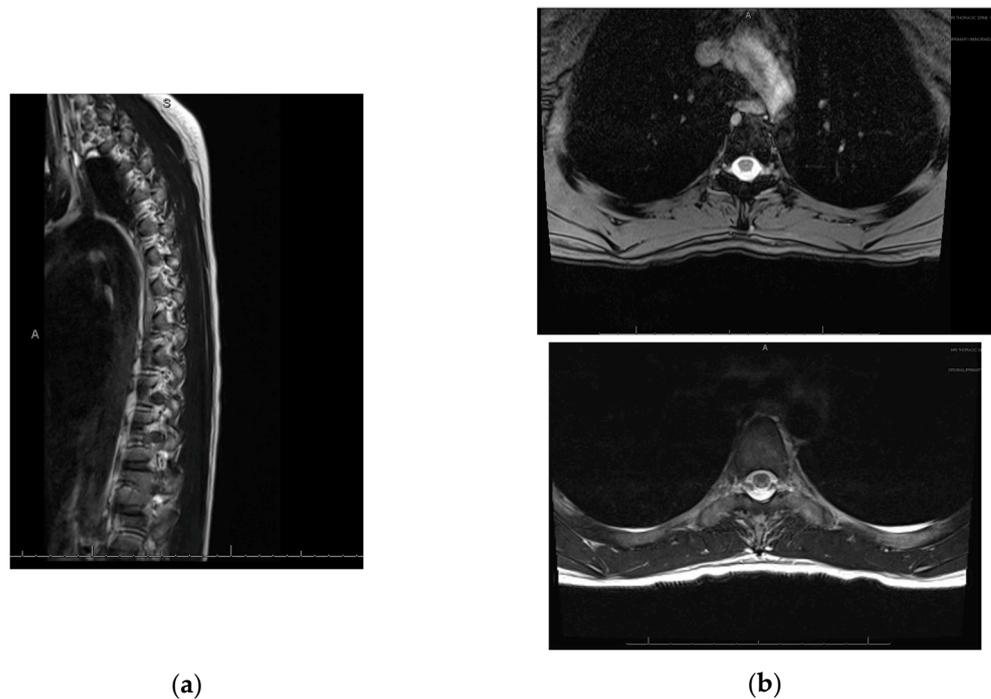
(a) Sagittal view of T2-weighted MRI of the thoracic spinal cord showing hyperintensity from T3 to conus medullaris. (b) T2-weighted transverse view of the thoracic spinal cord.
